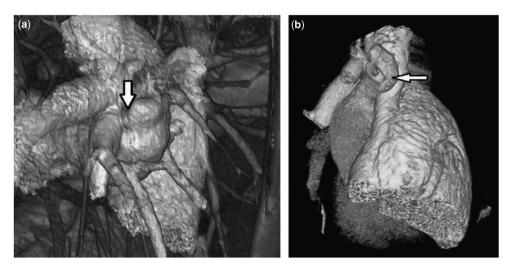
(a and b) CT scan with three-dimensional re-formatting, demonstrating the pulmonary arteriovenous fistula.
